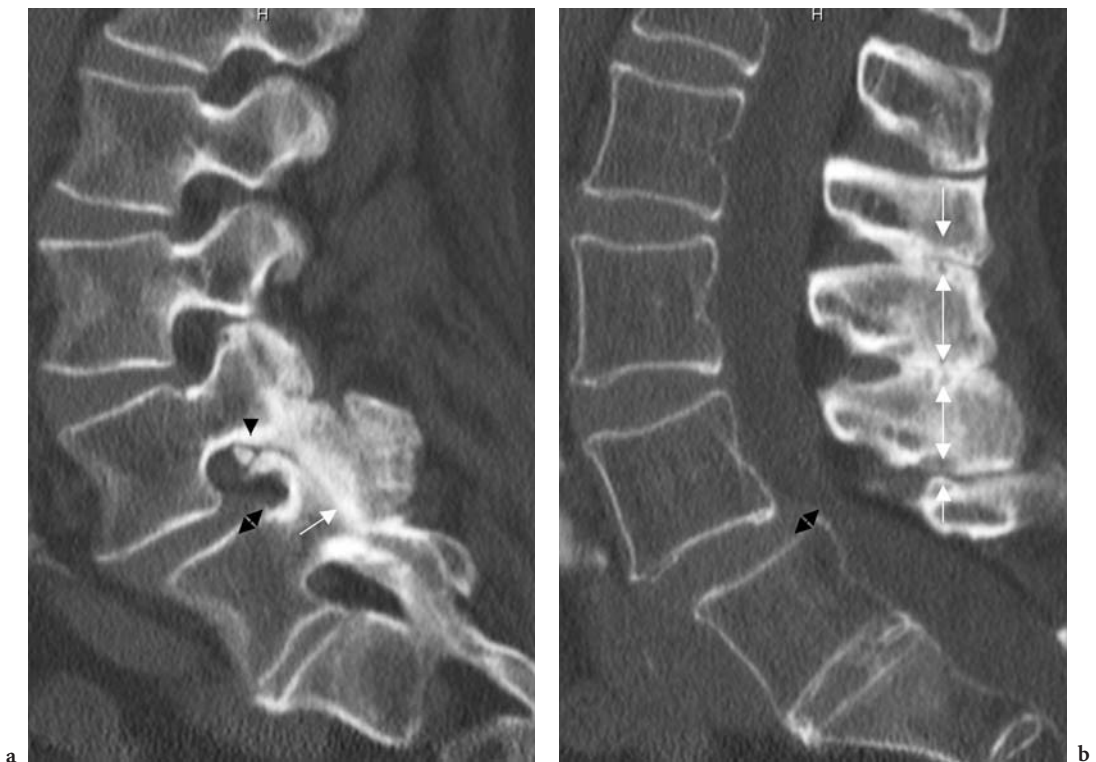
Neural arch intervertebral neoarthrosis. Sagittal reformatted CT images at the level of the facet joints (a) and in the midsagittal plane (b). Grade 1 degenerative spondylolisthesis at the L4–L5 level (*double arrows*). Curved remodeling associated with osteophytic overgrowth and fragmentation of the apex of the L5 superior articular process (*black arrowhead*) and abnormal bony contact and neoarthrosis formation with the inferior aspect of the L4 pedicle (a). Concomitantly, a neoarthrosis is formed between the apex of the L4 inferior articular process and the posterior aspect of the L5 pars interarticularis (*white arrow, a*). In the midsagittal plane (b), spinous process collision of adjacent vertebrae (*white arrows*) with progressive interspinous degenerative changes (Baastrup's phenomenon). Bulging of the posterior epidural fat with impressions on the posterior aspect of the thecal sac
